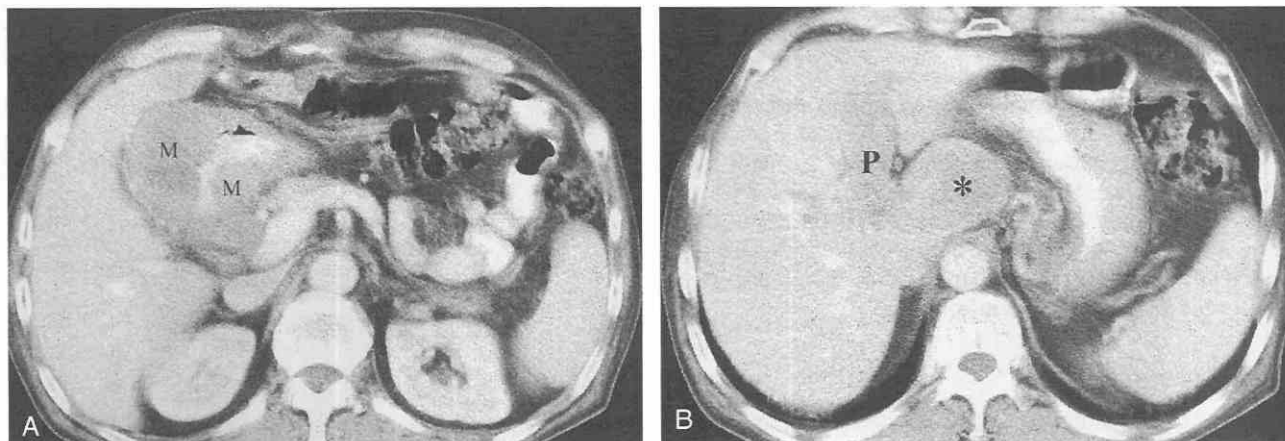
Hepatoid type of gastric adenocarcinoma. *A*, CT scan shows concentric gastric wall thickening (M) involving the antrum of the stomach. *B*, CT scan at a higher level shows a portal vein thrombus (P) and a metastatic lesion (asterisk) in the caudate lobe of the liver.
